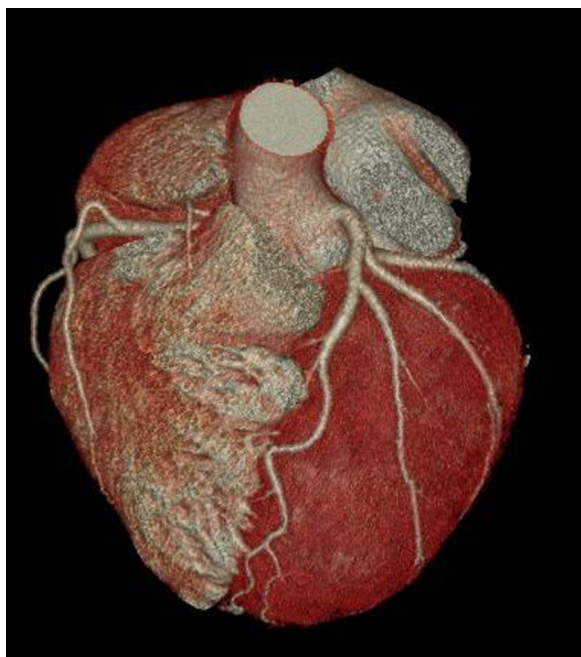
Three-dimensional volume-rendered CT image depicting normal coronary arteries.
